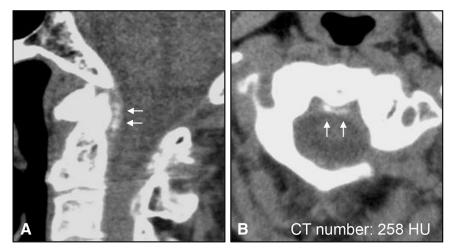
(Case 2) Computed tomography (CT) images of an 83-year-old woman with crowned dens syndrome (window level, 30 HU; window width, 250 HU). (A) Sagittal CT image showing calcifications in the transverse ligament of atlas. (B) Axial CT image showing calcifications surrounding the odontoid process (arrow). CT calcifications measure 258 HU (region of interest area: 1.8 mm²).
